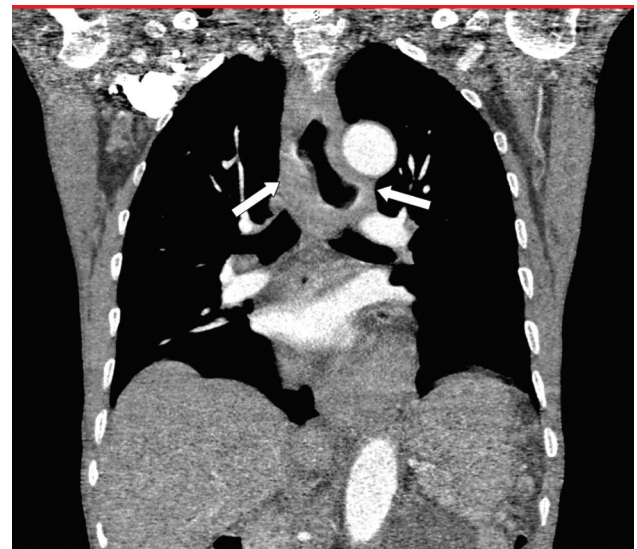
Coronal CT of the thorax shows symmetric wall thickening (arrows) in the mid-esophagus.
